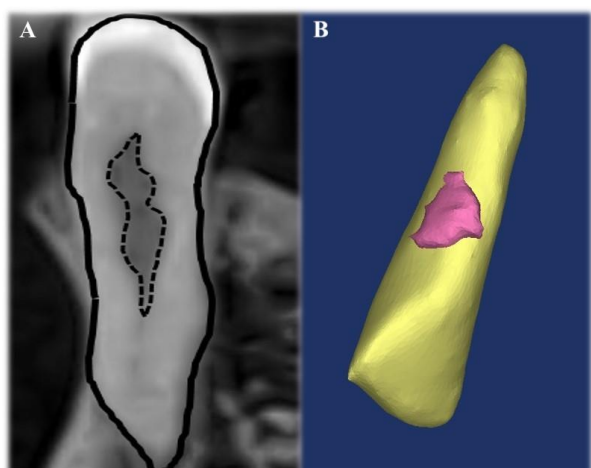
(A) Volumetric measurements of resorption and total tooth areas in a cross-sectional slice obtained from CBCT images of internal resorption case. (B) 3D reconstruction of resorption area and total tooth obtained during volumetric calculation with ITK-SNAP program in external cervical resorption case.
